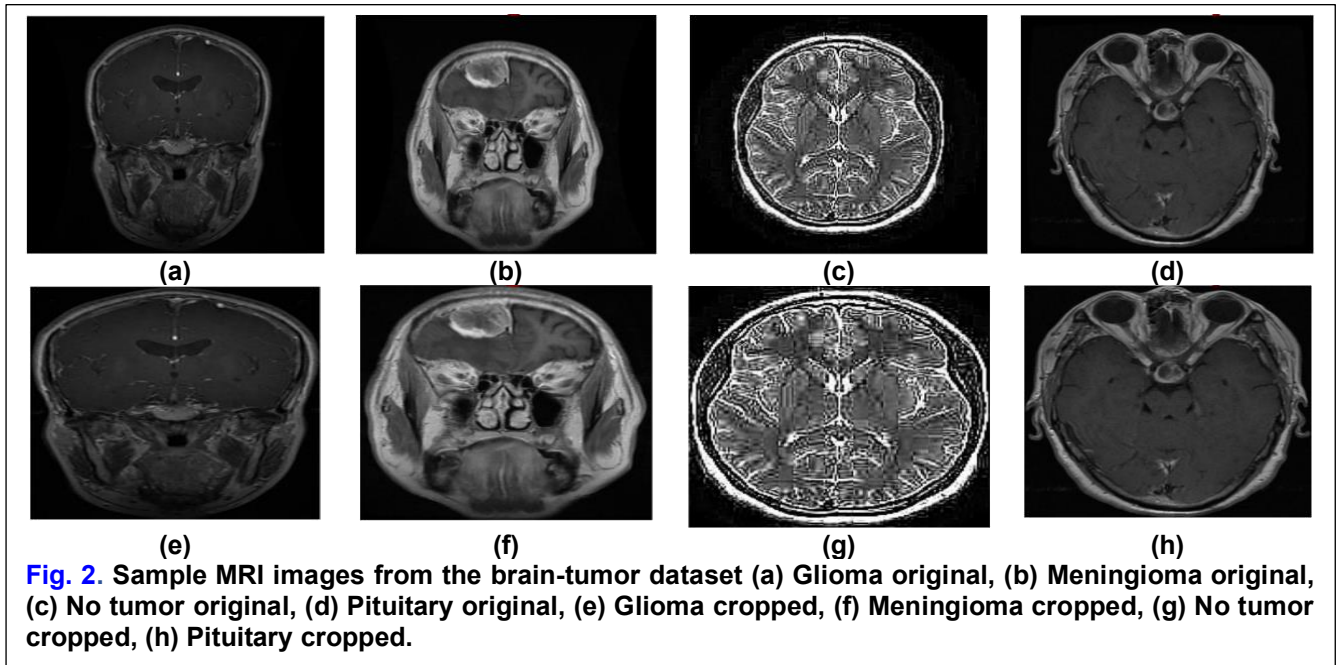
Sample MRI images from the brain-tumor dataset (a) Glioma original, (b) Meningioma original, (c) No tumor original, (d) Pituitary original, (e) Glioma cropped, (f) Meningioma cropped, (g) No tumor cropped, (h) Pituitary cropped.
